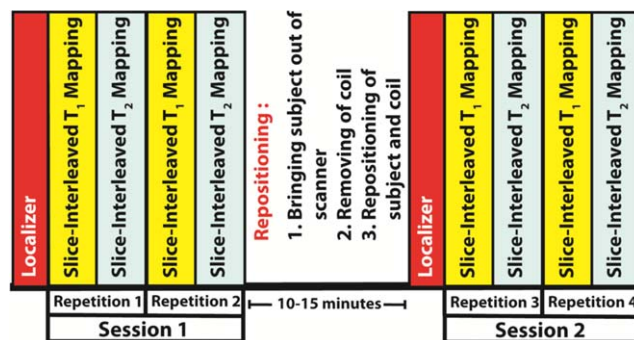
Study protocol: Healthy subjects ($n = 11$) underwent MR imaging to assess acquisition reproducibility between days, sessions, and repetitions. The study protocol was identical in both days. Each sequence was repeated twice per session. Between two different sessions, subjects were taken out of the scanner, and the 32-channel phased array coil was repositioned before starting the next session.
